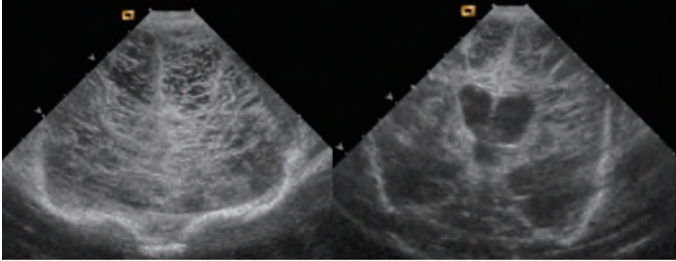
Ultrasound images showing the extensive cortical damage
